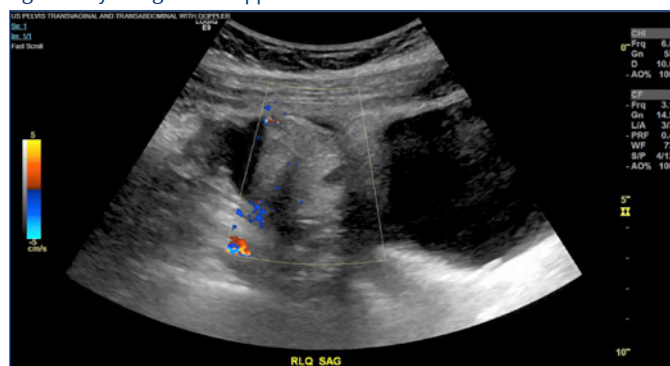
Comprehensive ultrasound (US). No flow is visualized to the right ovary using color doppler.
